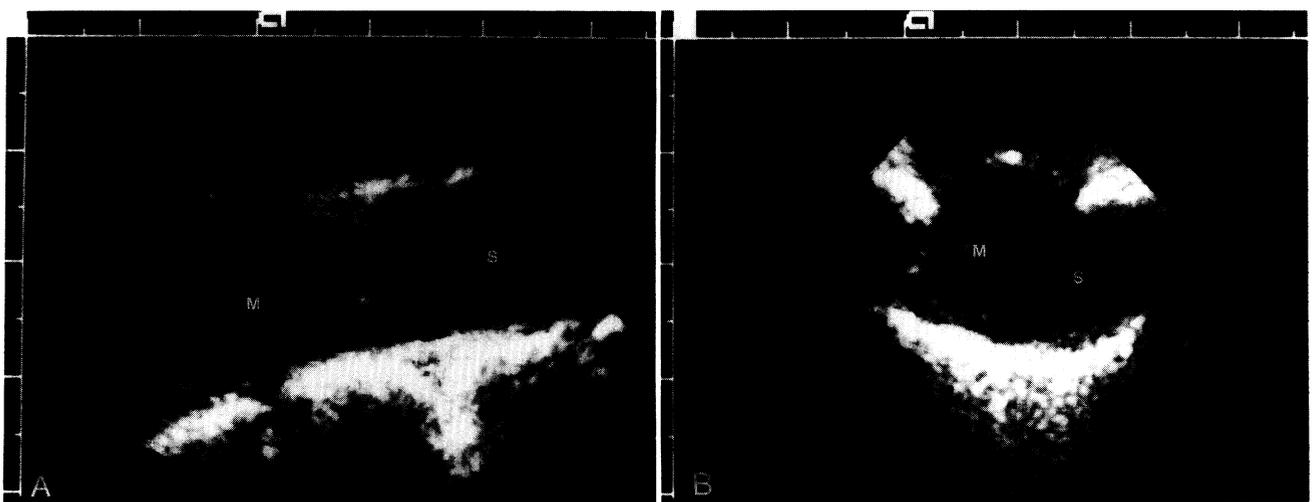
Longitudinal (A) and transverse (B) sonograms of an extramedullary mass (M) displacing the spinal cord (S) to the left. The mass proved to be a neurofibroma.
